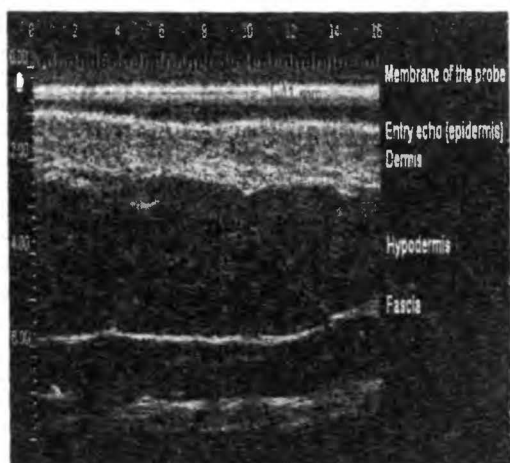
Ultrasound examination of normal skin.
